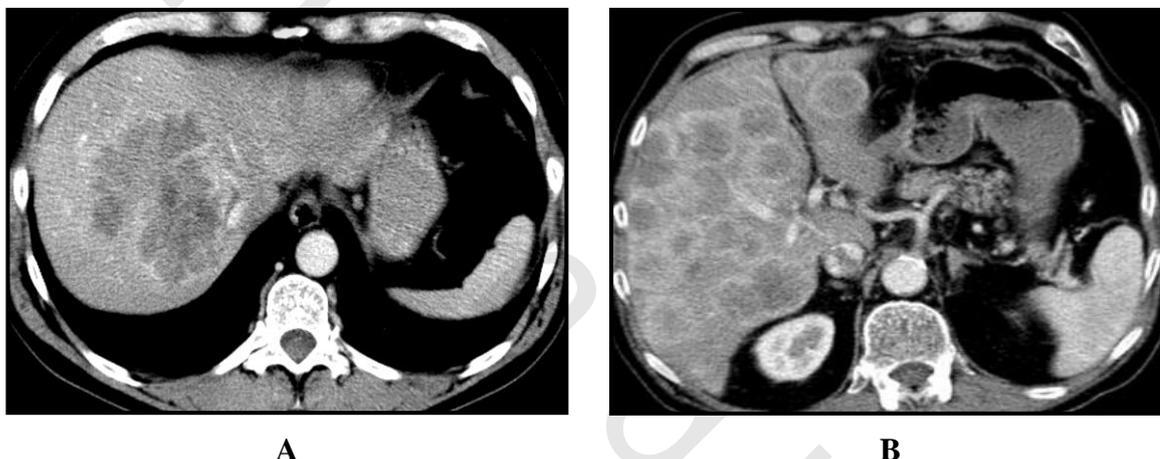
A) Axial contrast-enhanced CT scan of a 58-year-old patient with colon cancer shows a lobulated and ill-defined liver metastasis. B) Axial contrast-enhanced CT scan of a 74-year-old patient with rectal cancer shows confluent liver metastases⁽⁴⁰⁾.
